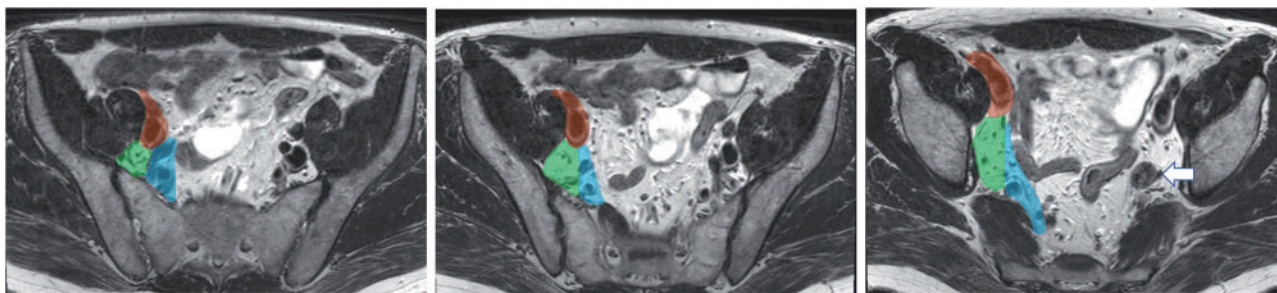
MRI of lateral lymph nodes
